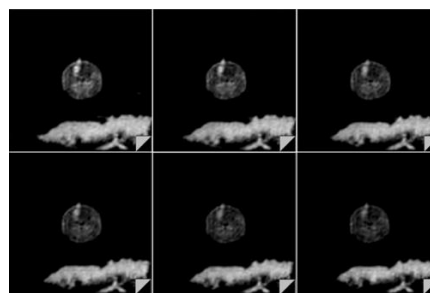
T1-weighted images taken every 10-minutes over 1 hour, showing AGuIX contrast enhancement of the tumour
